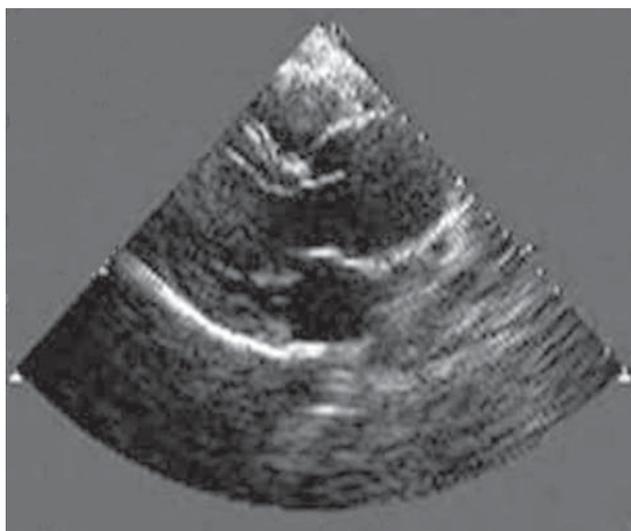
Parasternal long-axis view in systole. Note the dilated aortic root and ascending aorta.
